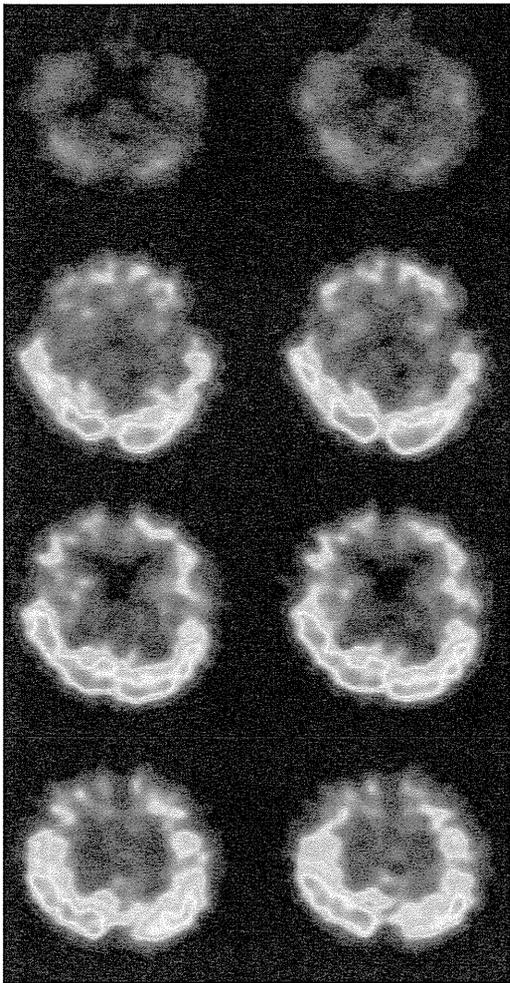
^{99m}Tc-ethyl cysteinyl dimer single-photon emission computed tomography of a female Japanese Canavan disease patient. The frontal decrease in cerebral blood flow is characteristic. This was obtained from the same case as in Figures 1,2.
